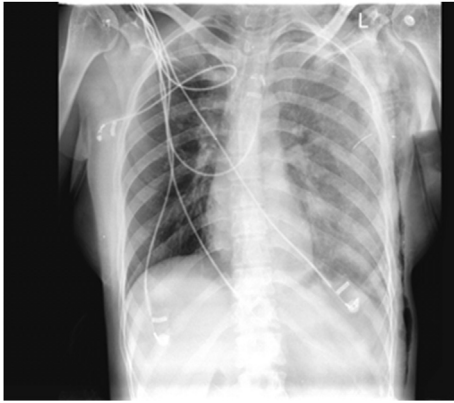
Portable chest x-ray in the Emergency Service demonstrating left hemothorax.
